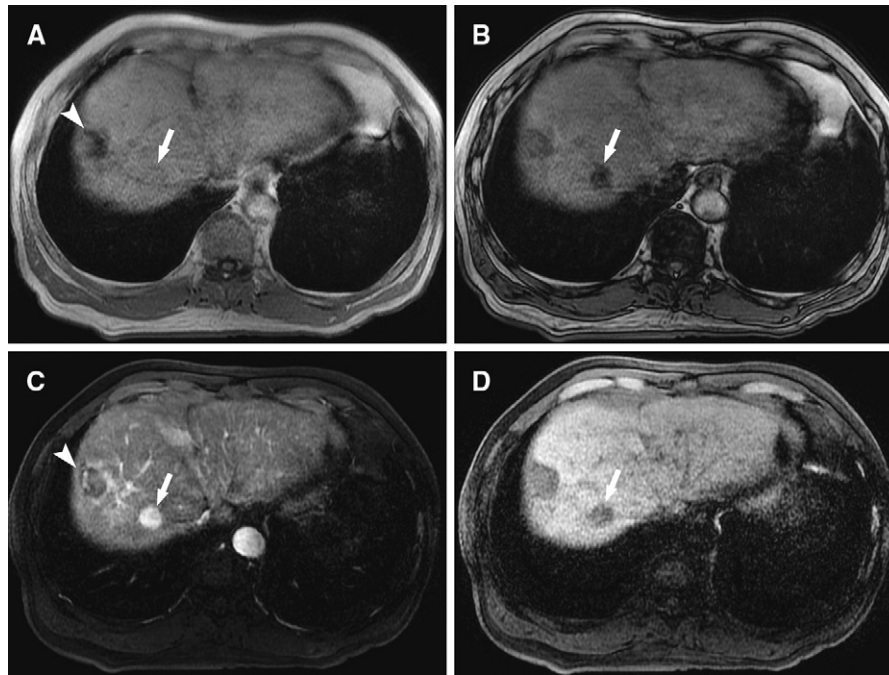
(A) Axial gradient echo T1 in phase sequence with an isointense mass located in segment 7, exhibiting signal intensity drop out on out-of-phase sequence (B) consistent with intracytoplasmic fat (arrows). There is an additional hypointense mass located within the lateral aspect of segment 7 (arrowheads). (C) Gadolinium-enhanced liver acceleration volume acquisition magnetic resonance image during the arterial phase, which demonstrate hypervascularity of the mass (arrows) with corresponding washout on the portal venous phase (D). The additional lesion (arrowheads), showing progressive centripetal filling throughout the phases (not all images shown) consistent with a cavernous hemangioma.
